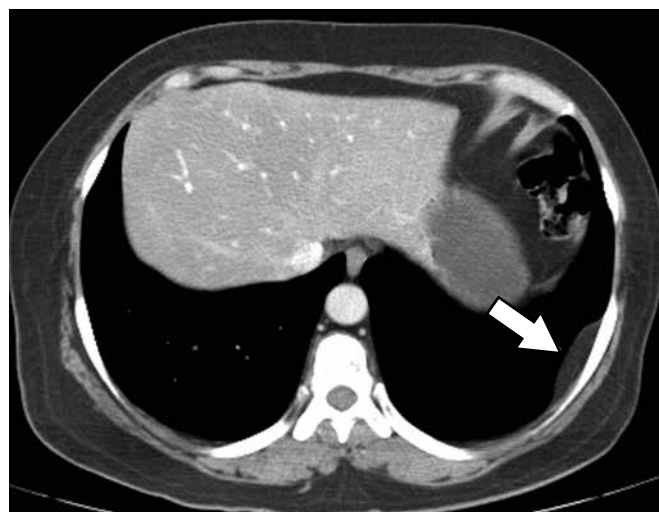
a) Axial cut CT: Low fat density image, localized in the left superficial pleura corresponding to lipoma (arrow).
